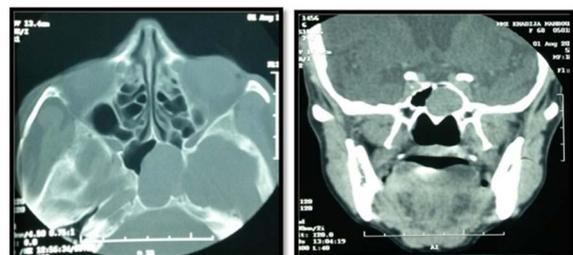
Axial and coronal CT scan imaging demonstrating a mucocoele of the sphenoid sinus.
